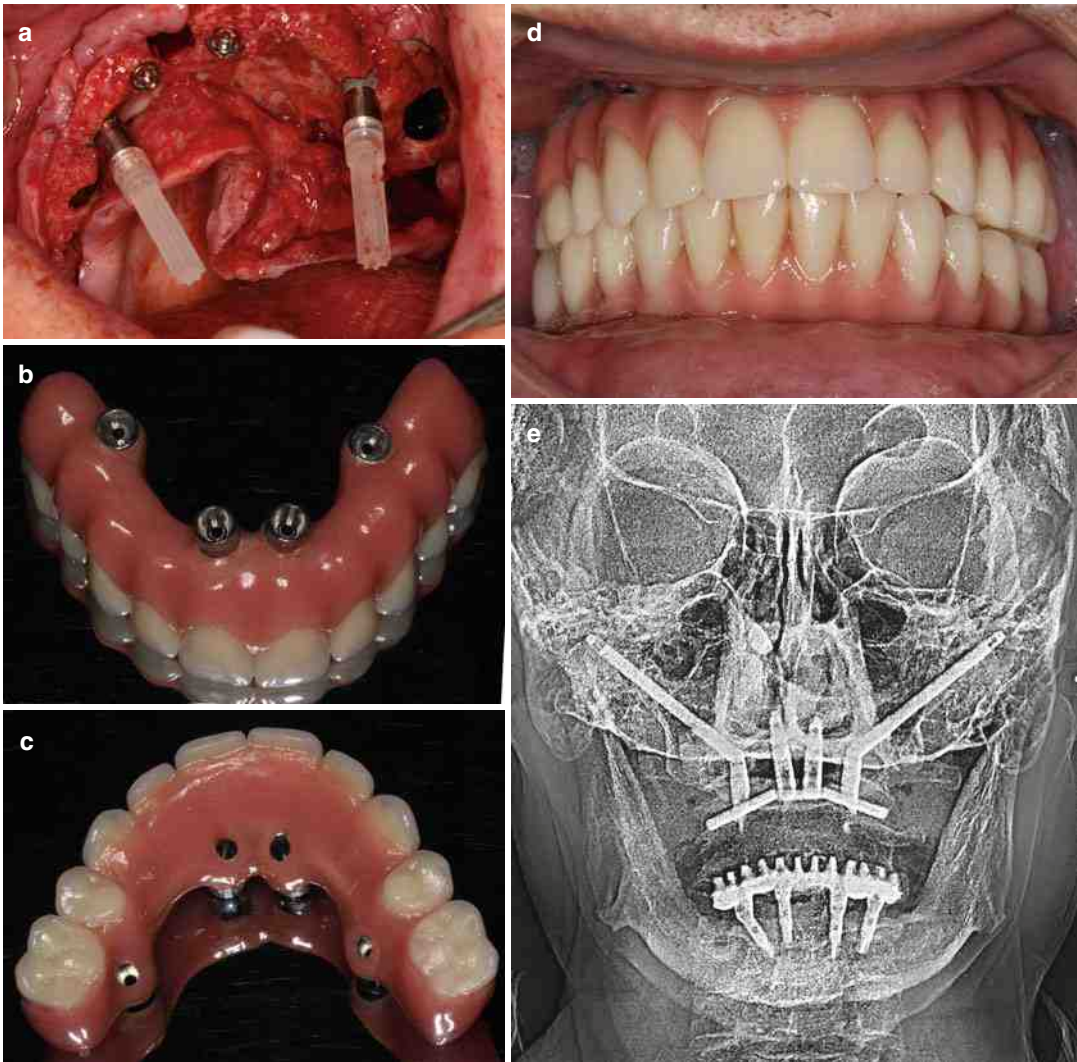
(a–e) Zygomatic implant placement (a). Maxillary prosthesis (b, c). Delivery of the prosthesis and X-ray showing the correct placement of the implants up to the zygomatic bone (d, e)
